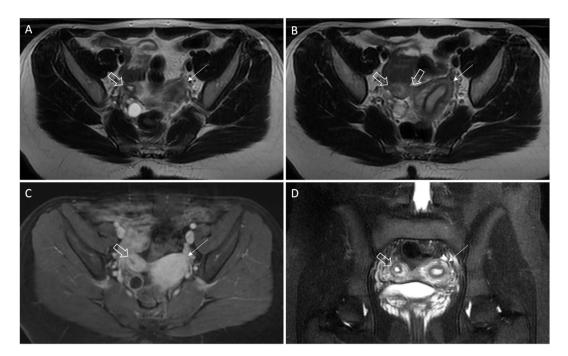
Axial T2WI MRI (A, B), axial contrast-enhanced FS T1WI MRI (B), and coronal FS T2WI MRI (D) show a normal-appearing left uterine horn (thin arrows) and a right side pelvic structure connected with the myometrium (thick open arrows). This is a rudimentary horn that contains zonal anatomy and endometrium. Axial T1WI C+ FS MRI (C); dominant and rudimentary horns show normal myometrial enhancement.
